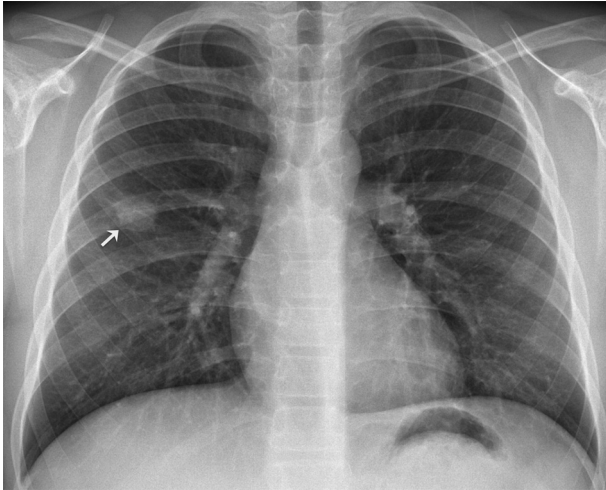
Posteroanterior chest radiograph depicts a solitary pulmonary nodule in the middle third of the right hemithorax (arrow). Slight spiculation of its contour can be appreciated.
